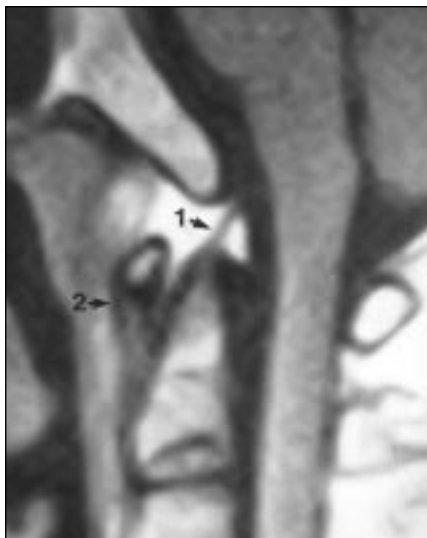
Normal anatomy in 21-year-old man. Sagittal T1-weighted MR image (TR/TE, 510/25) obtained on 0.3-T scanner shows normal apical ligament (1) and anterior atlantoaxial membrane (2).
